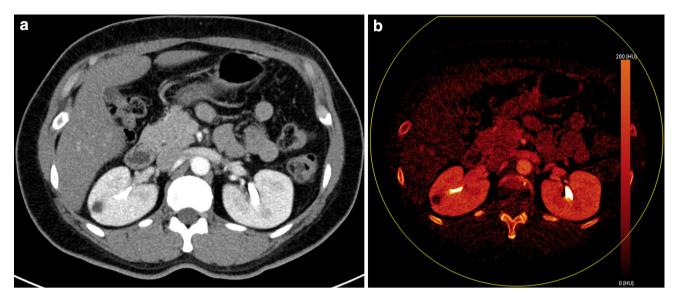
a Triple-bolus contrast CT scan done in a 35-year-old female with hematuria shows a simple cyst in the right kidney. b On the 'iodine overlay' images generated on post-processing software, the cyst shows no iodine uptake, confirming absence of intralesional enhancement
